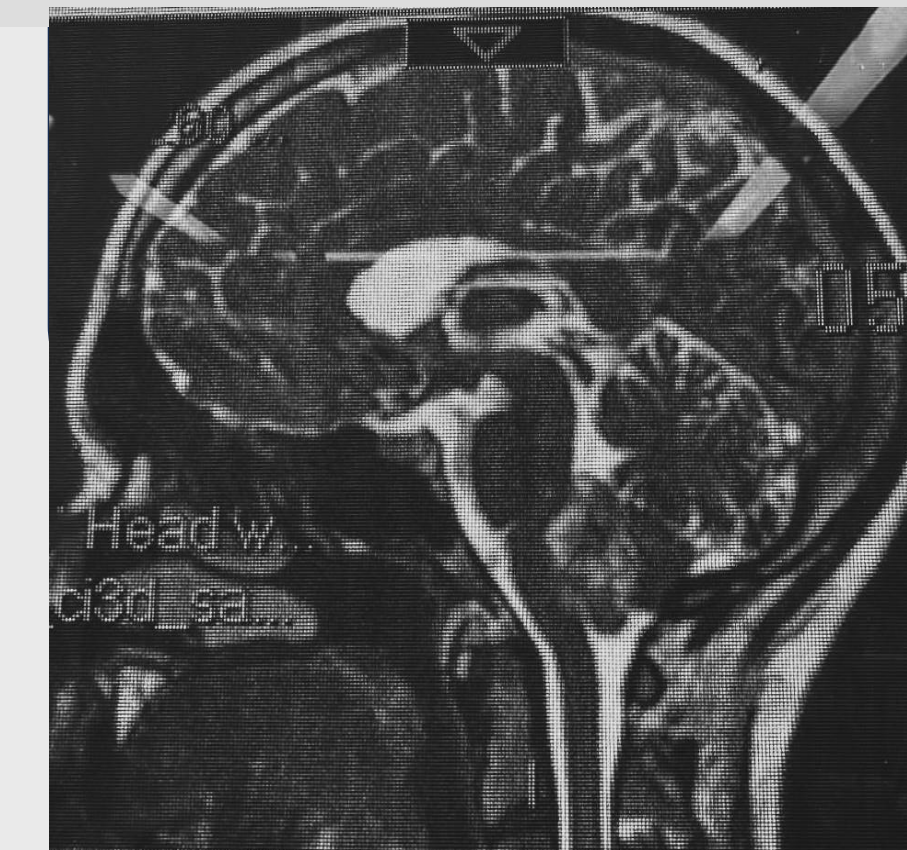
MRI scan (sagittal)
